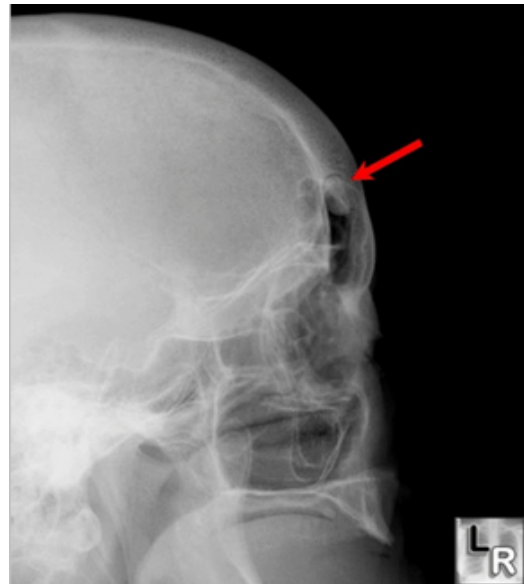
X-ray Skull, Lateral View: Osteoma of Left Frontal Sinus
